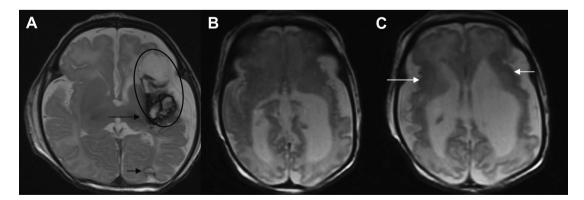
(A) Axial T2-weighted image from a 6-week-old infant showing haemorrhagic stroke (circle) within the territory of the left middle cerebral artery. The lesion is already atrophic indicating that it is at least 3–4 weeks old. The posterior limb of the left internal capsule is not normal (arrow) and the basal ganglia are smaller than on the right making it highly likely that the child will develop contralateral hemiplegia. There is another smaller lesion posteriorly (short arrow) and one (not shown) on the medial border of the anterior lobe. (B, C) Axial T2-weighted images at the level of the lower basal ganglia (B) and mid-ventricular level (C) from a growth-estricted infant with hypoplastic left heart syndrome. There is marked irregular lateral ventriculomegaly. The white matter is severely reduced in volume and of abnormally high signal more posteriorly. The cortex is clearly abnormal with the appearance of polymicrogyria (arrows) bilaterally in the periSylvian regions. (Images reproduced by courtesy of S.O. Algra MD; UMC Utrecht).
